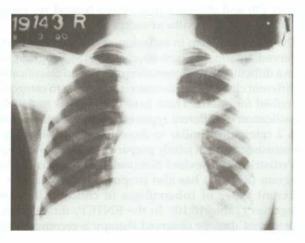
X-ray film of primary pulmonary complex showing left hilar adenopathy and ill-defined parenchymal lesion
